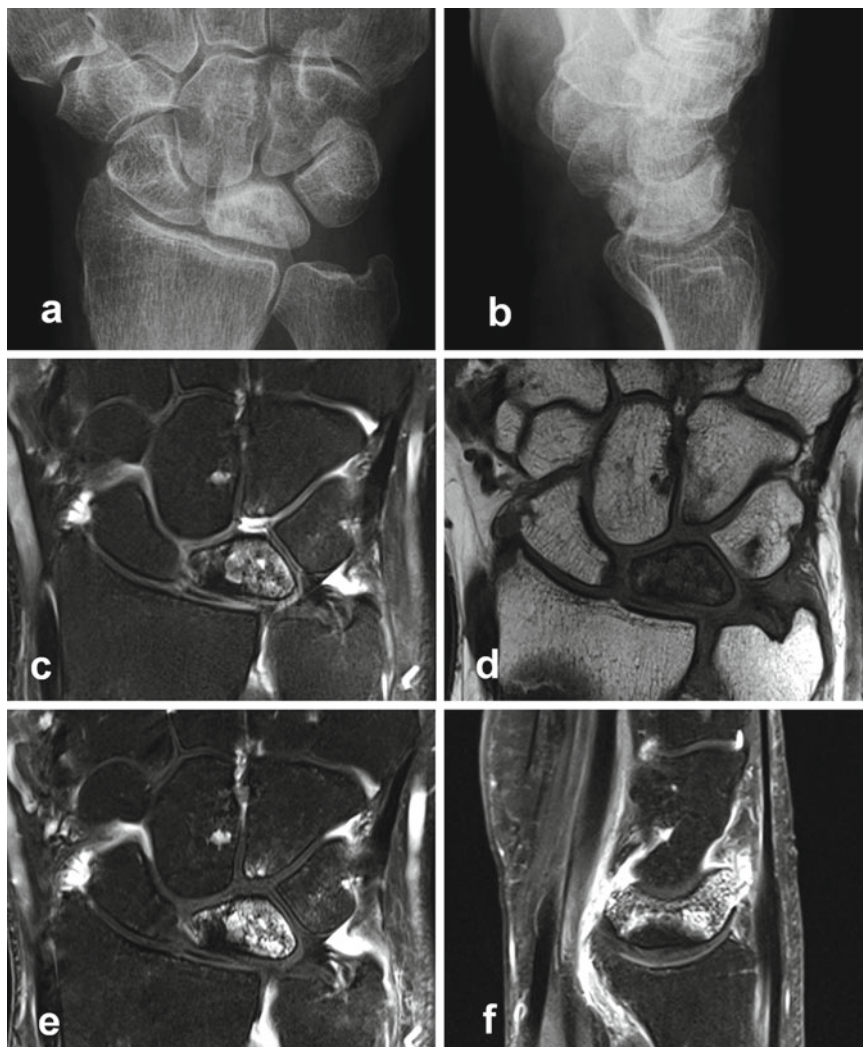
Partial lunate necrosis (MRI pattern B) in stage IIIb of Kienböck's disease. Patient is a 56-year-old male with a painful swollen wrist. Both necrotic and repair zones are located side by side. (a, b) In dorsopalmar and lateral radiographs, the lunate is diffuse osteosclerotic and flattened at its proximal circumference. (c) The hypointense proximal zone of the lunate is evident, while there is marked bone-marrow edema in the middle and distal parts (coronal PD-w FSE fat-saturated). Type II
